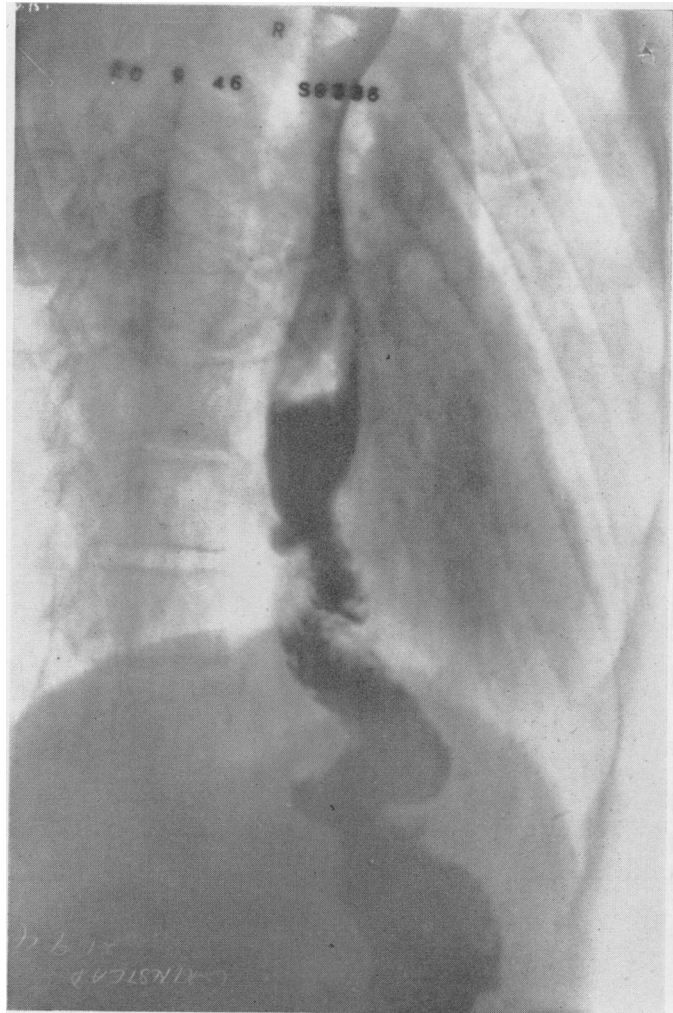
X-ray of barium swallow after abdominal total gastrectomy, and end to end oesophagojejunostomy showing resection of lowest oesophagus.
